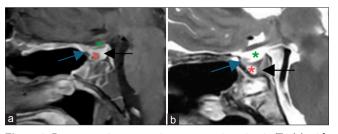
Post-operative magnetic resonance imaging in T1 (a) with contrast and T2 (b) in sagittal projections shows the red asterisk indicating the tumor resection cavity, the blue arrow pointing to the normal anterior pituitary lobe, and the black arrow representing the normal posterior pituitary lobe. The green asterisk depicts optic nerve decompression.
